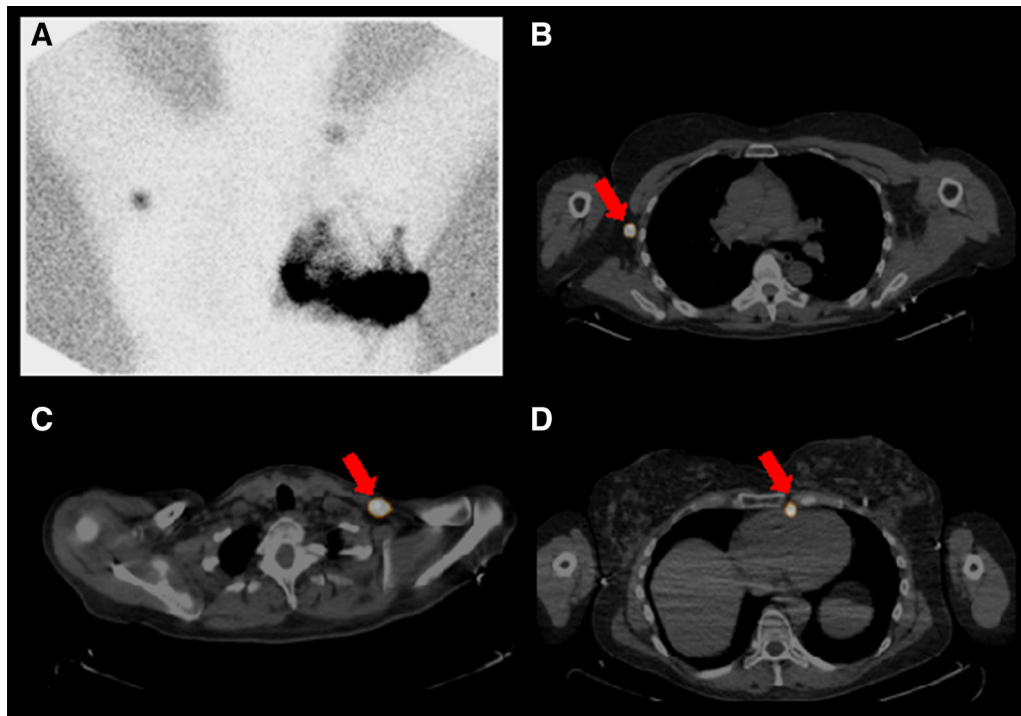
Single-photon emission computed tomography (SPECT) of the breast. A patient aged 50 years after left lumpectomy with left axillary nodal dissection with recurrent left breast cancer undergoing left breast lymphoscintigraphy. Lymphoscintigraphy shows extensive heterogeneous tracer accumulation throughout the skin of the left breast, including multiple serpiginous trails of activity as well as irregular accumulations (A). Additionally, isolated foci are seen in the right axillary region and lower left neck. SPECT and computed tomography localize these two foci to the right axilla (B) and left supraclavicular region (C). Additionally, a left internal mammary node was visualized (D).
